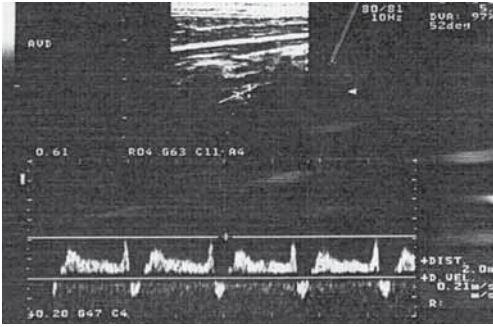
Duplex ultrasound of the right vertebral artery: there is a reverse flow in late systole (the 'to and fro' pattern), indicating partial subclavian steal syndrome.
